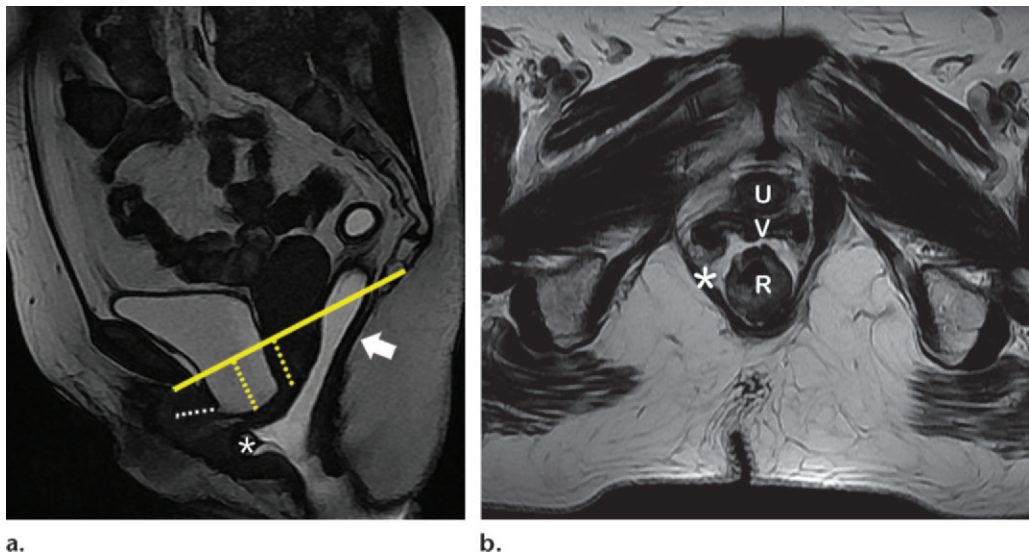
Pelvic organ prolapse in a 47-year-old woman with stress urinary incontinence. (a) Sagittal FIESTA MR image at defecation shows a moderate cystocele and mild uterine prolapse (dotted yellow lines) with respect to the PCL (solid yellow line). Angulation of the urethral axis (dotted white line) results in urethral hypermobility in the anterior and middle compartments. In the posterior compartment, descent of the anorectal junction with consequent elongation of the *H* and *M* lines (not marked), angulation of the levator plate, and a moderate anterior rectocele (*) are present. (b) Axial T2-weighted image at the level of the proximal urethra shows thinning of the right aspect of the puborectalis muscle (*), which is nearly detached from the pubic bone. *R* = rectum, *U* = urethra, *V* = vagina.
